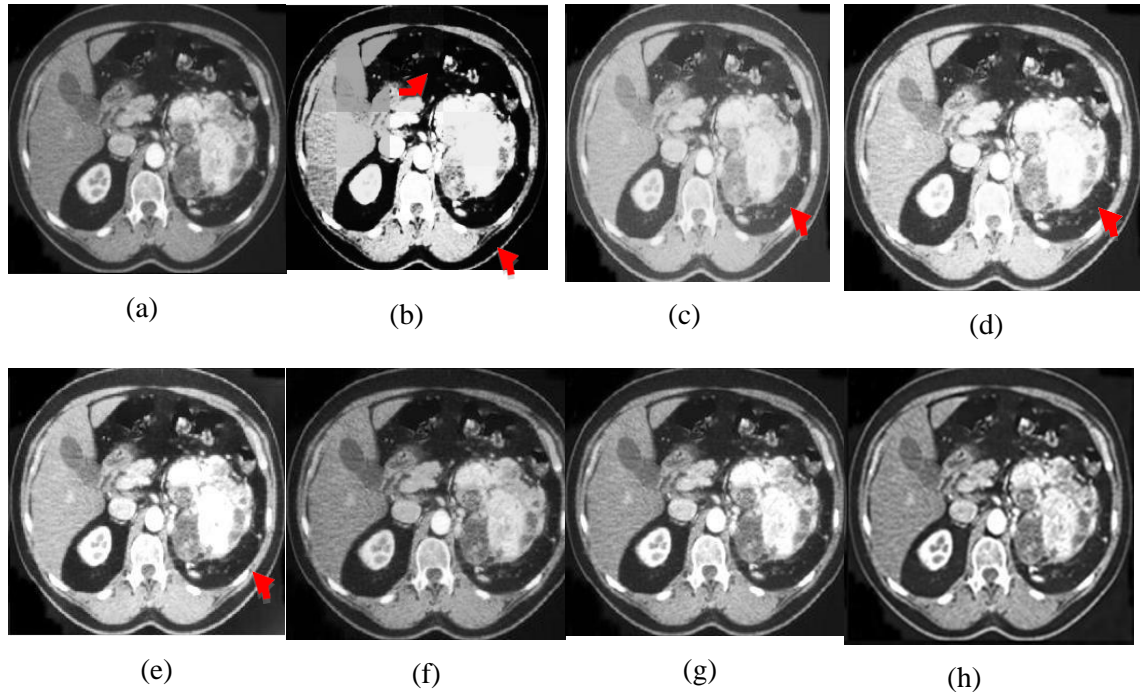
Experiment outcomes of the 'CT-2' Image (a) Original image, (b) S-curve, (c) AGC-DWT, (d) AGC-WHD, (e) GAGC-DWT, (f) EBCHE, (g) TCHE-DWT, (h) Proposed scheme
